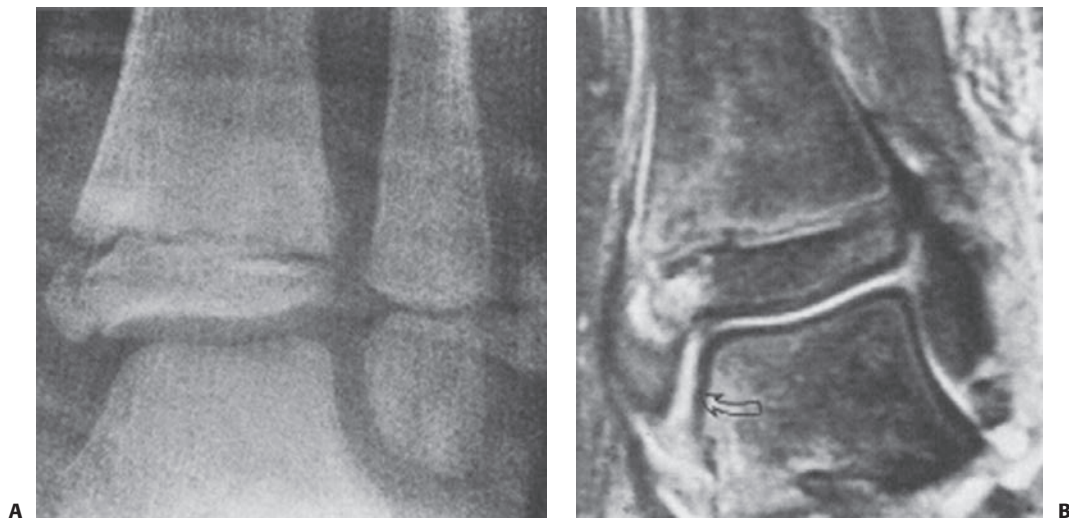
A: Follow-up radiograph of a 7-year-old boy 1 week after an initially nondisplaced Salter–Harris type III fracture from a supination–inversion injury of the distal tibia. B: Because of the incomplete ossification of this area and concern that the fracture might have displaced, MRI was performed. Note that the distance between the medial malleolus and the talus is greater than the distance between the talus and the distal tibia or lateral malleolus, confirming displacement of the fracture.
